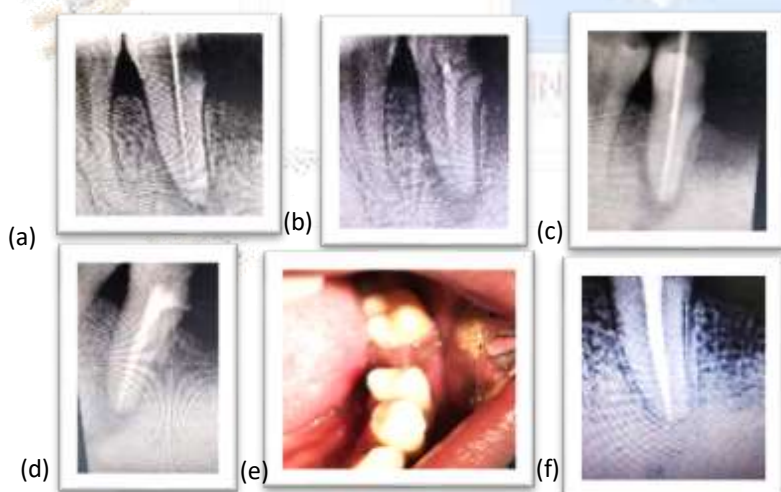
(a) working length radiograph
